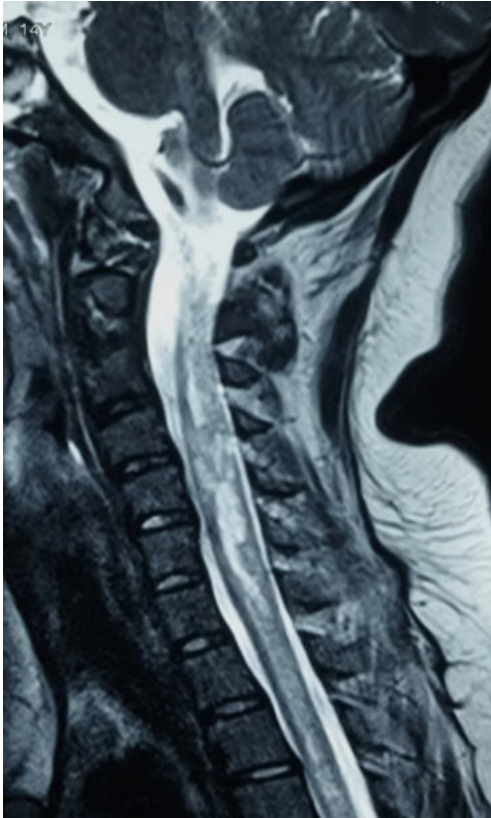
Sagittal MRI view of the patient showing longitudinally extensive transverse myelitis in cervical cord with extension upto the cervico-medullary junction.
